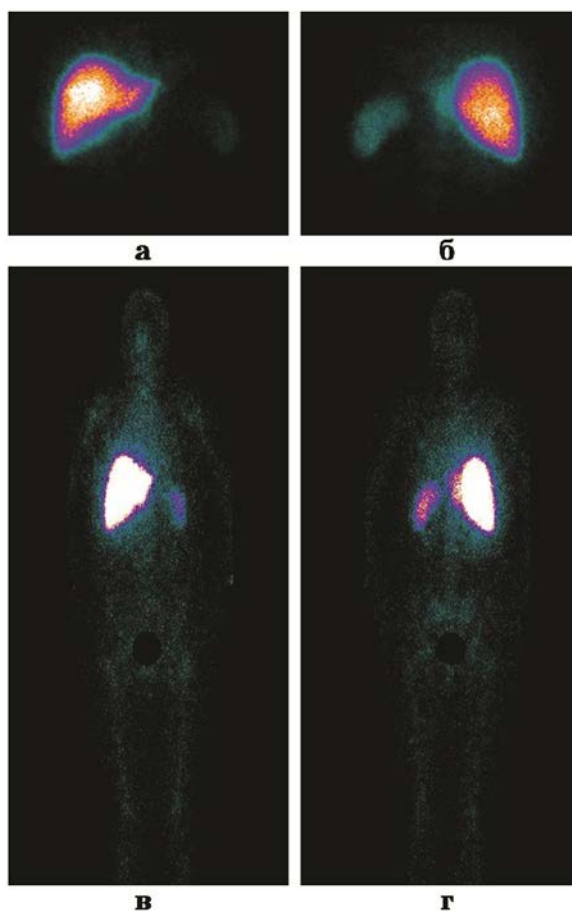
The scintigrams of the normal liver and spleen in the anterior (a) and posterior (b) views in examined Patient B. of 33 years old; scintigrams in the anterior (c) and posterior (d) views taken in the "whole body" mode
